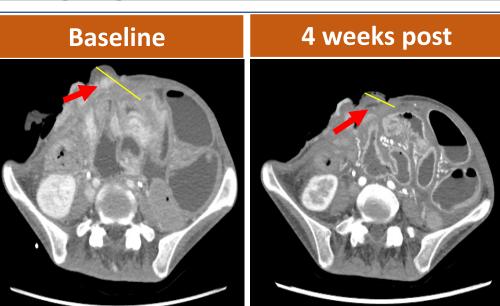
A 48-year-old female with metastatic GC was previously diffuse FOLFOX. FOLFIRI treated with capecitabine, zolbetuximab (CLDN18.2 antibody), pembrolizumab + cabozantinib, and nab-paclitaxel. CLDN18.2 IHC showed 2+ 5% and 3+ 95%. CT showed a 7.6 cm mass extended through stoma to the exterior abdominal surface. CT 4 weeks post CT041 showed significant tumor reduction in exterior stoma lesions.
